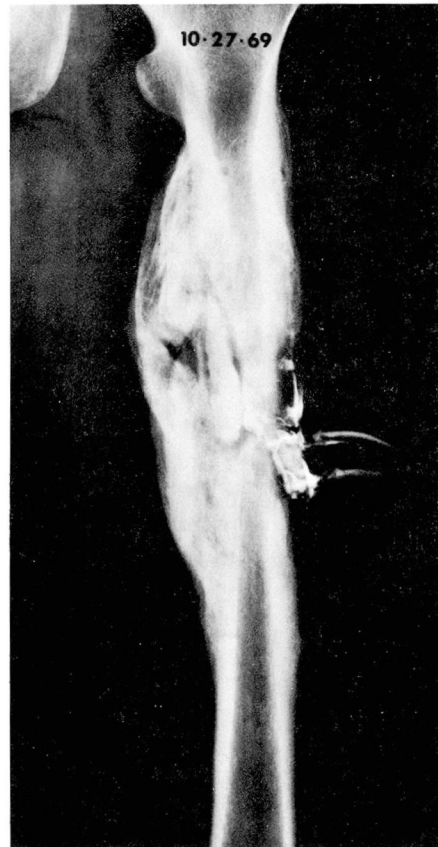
Roentgenogram of the left femur, October 27, 1969, showing marked periosteal reaction, four radioopaque sequestra and a radiolucent area of cortical destruction lateral to the largest of the sequestra.
